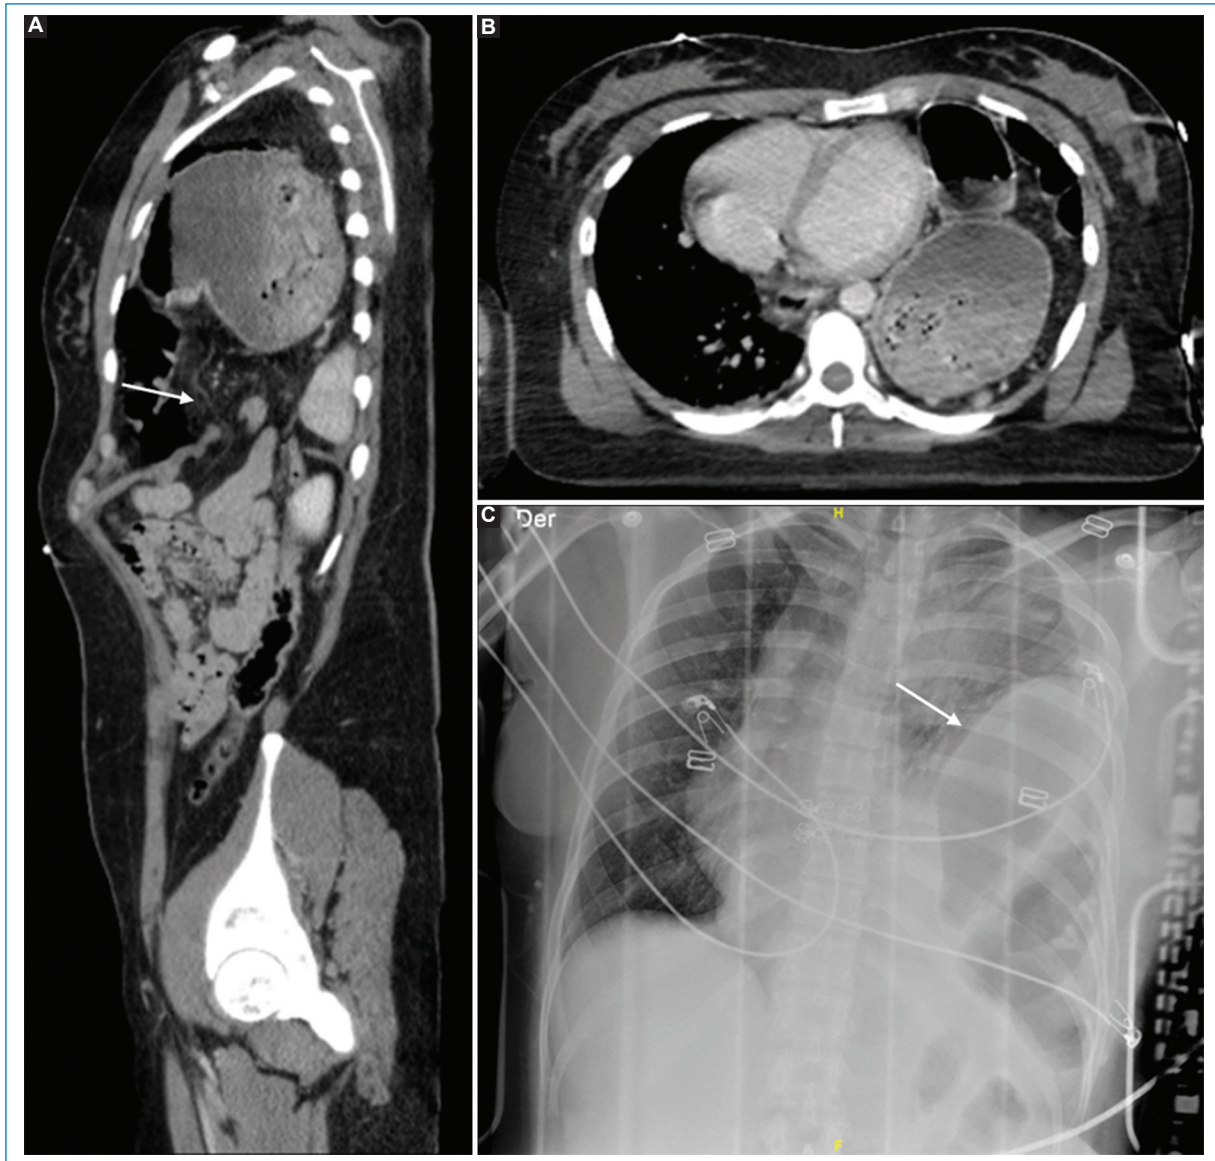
Blunt mechanism traumatic hernia. Sagittal reconstruction (A), axial slice (B) and portable chest X-ray (C). Diaphragmatic discontinuity with ascent of abdominal contents into the thoracic cavity and the “hourglass” sign can be seen on the sagittal reconstruction (white arrows).
